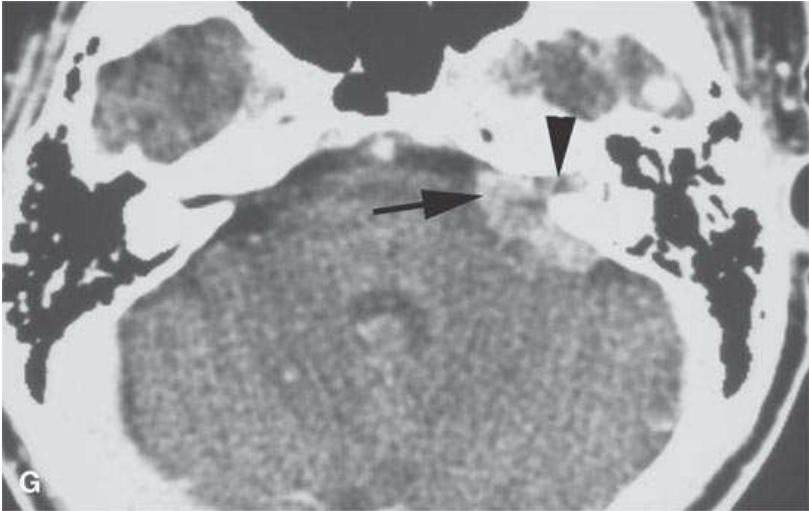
Contrast-enhanced computed tomography showing diffuse leptomeningeal dissemination of Merkel cell carcinoma.
